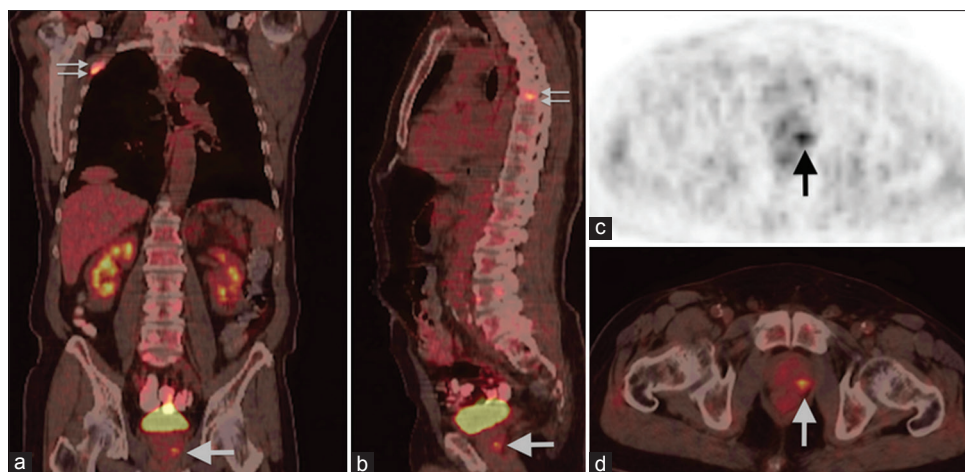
Coronal and sagittal fusion (a and b), and axial positron emission tomography (PET) and fusion (c and d) slices of PET/computed tomography demonstrating hypermetabolic focus in the left peripheral zone of the prostate gland (arrows), and increased fluorodeoxyglucose uptake in the right 2nd rib and 7th thoracic vertebrae
